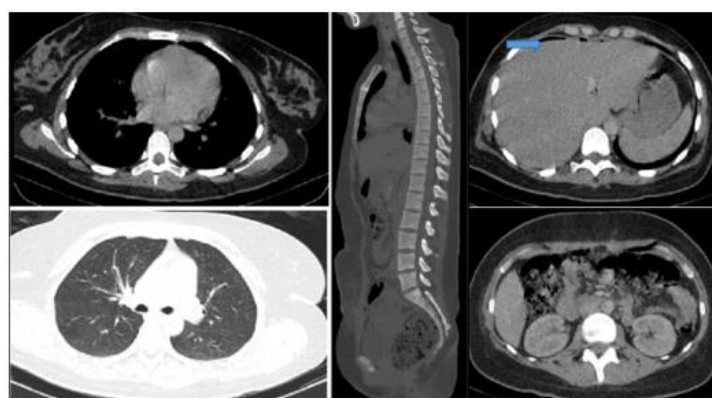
Thoraco-abdominopelvic computed tomography demonstrated a non invasion of adjacent pelvic organs, lymph node enlargement, or distant metastatic lesions including pulmonary, hepatic, or osseous involvement were identified. Postoperative changes were noted, including pneumoperitoneum [blue arrow].
